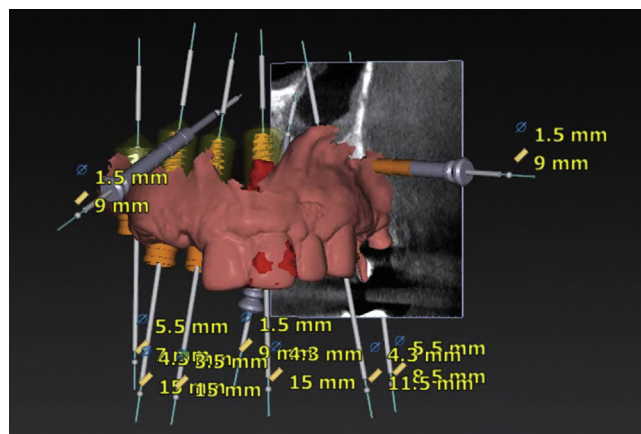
STL file obtained from intraoral scanner and DICOM file obtained from CBCT imported to implant planning program for initial phase of treatment planning. CBCT, cone beam computed tomography; DICOM, Digital Imaging and Communications in Medicine; STL, standard tessellation language.
